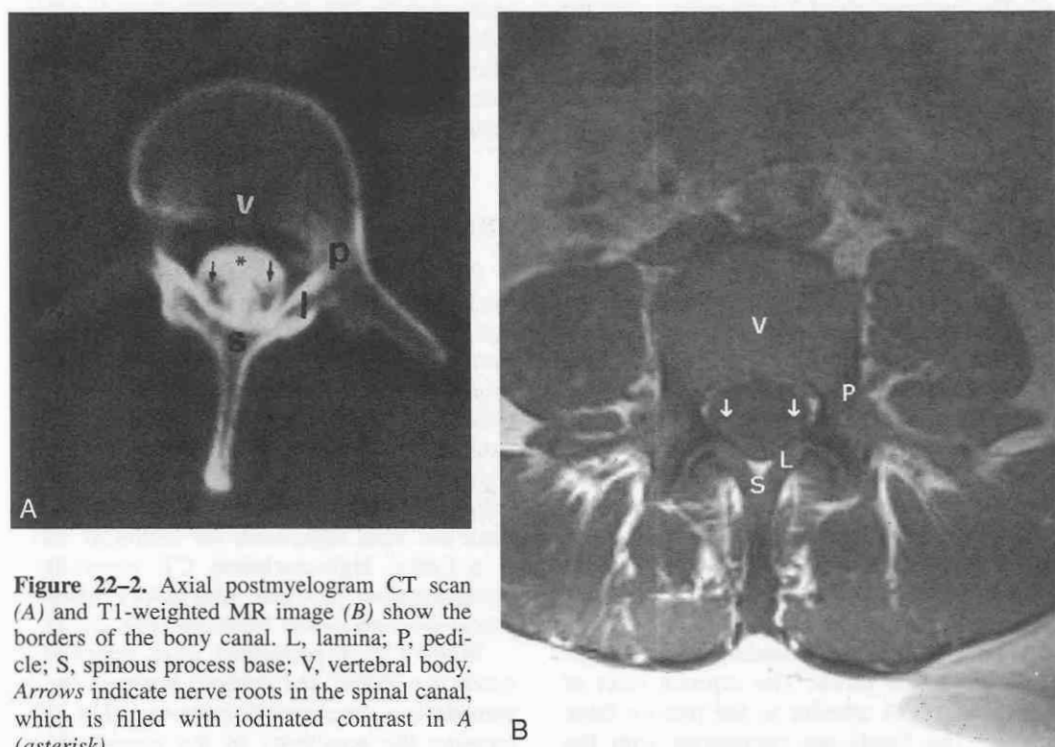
Axial postmyelogram CT scan (A) and T1-weighted MR image (B) show the borders of the bony canal. L, lamina; P, pedicle; S, spinous process base; V, vertebral body. Arrows indicate nerve roots in the spinal canal, which is filled with iodinated contrast in A (asterisk).
